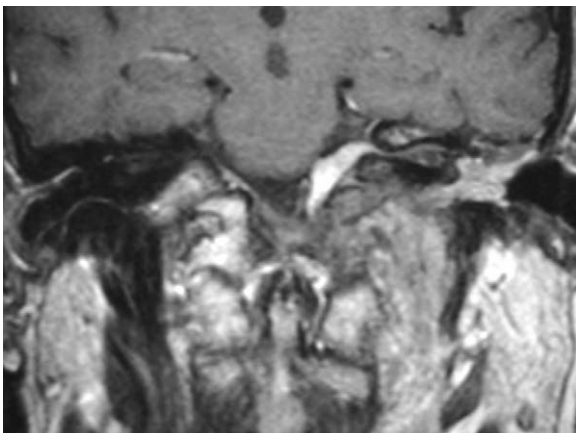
Post-gadolinium, T1-weighted, coronal image demonstrates enhancing meningioma in the inferior left cerebellopontine angle cistern with enhancement extending into the IAM. There is further extension of the meningioma to fill the left middle ear cavity (other images demonstrated this tissue to be continuous with that in the jugular foramen).
